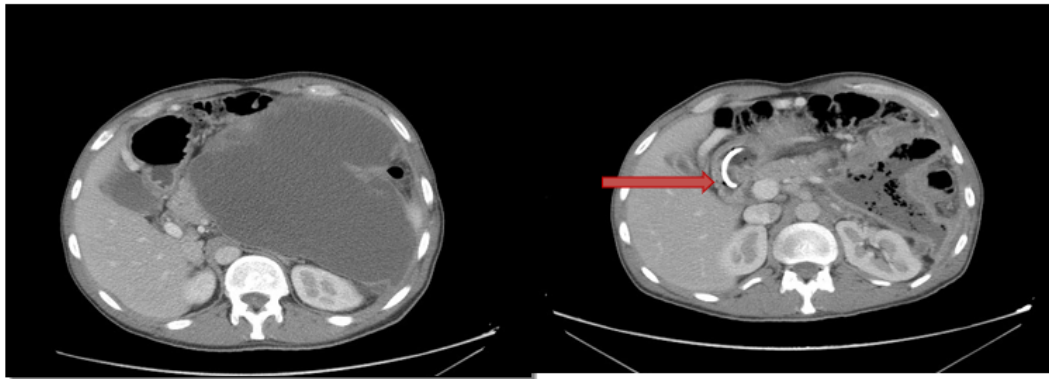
a-CT scan: before endoscopic drainage; b-CT scan: decrease of the collection after endoscopic drainage with stent pigtail in place (fleche).
